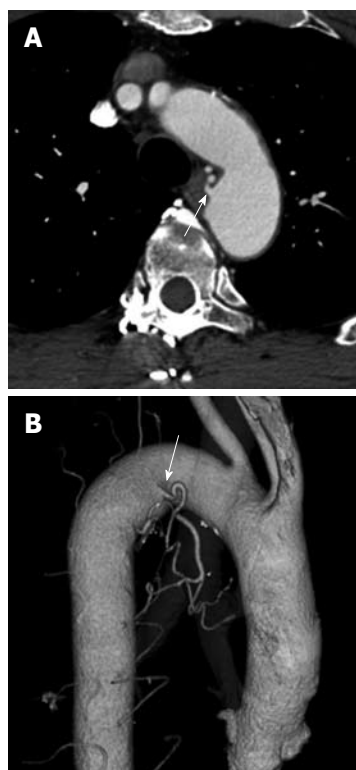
Common trunk of the right and left bronchial arteries from the aortic arch is indicated by arrows on an axial computed tomography image with mediastinal soft-tissue window settings (A) and on a thin-section maximum intensity projection image of a three-dimensional volumetric reformatted image (B).
